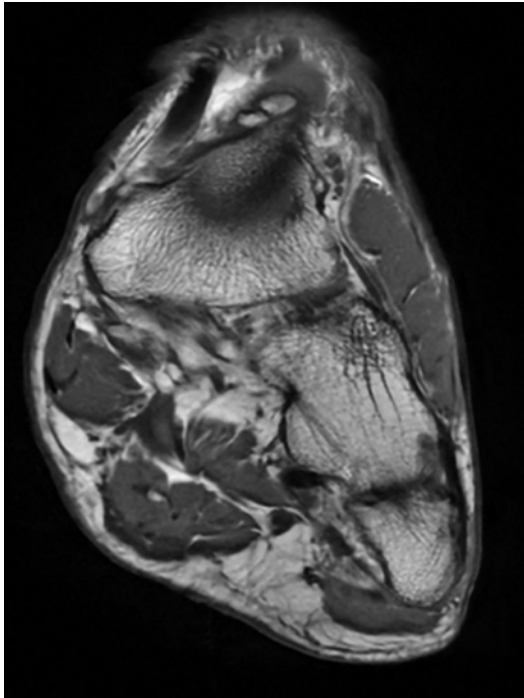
Five-year follow-up magnetic resonance imaging (T1 coronal view) showing os supranaviculare.
